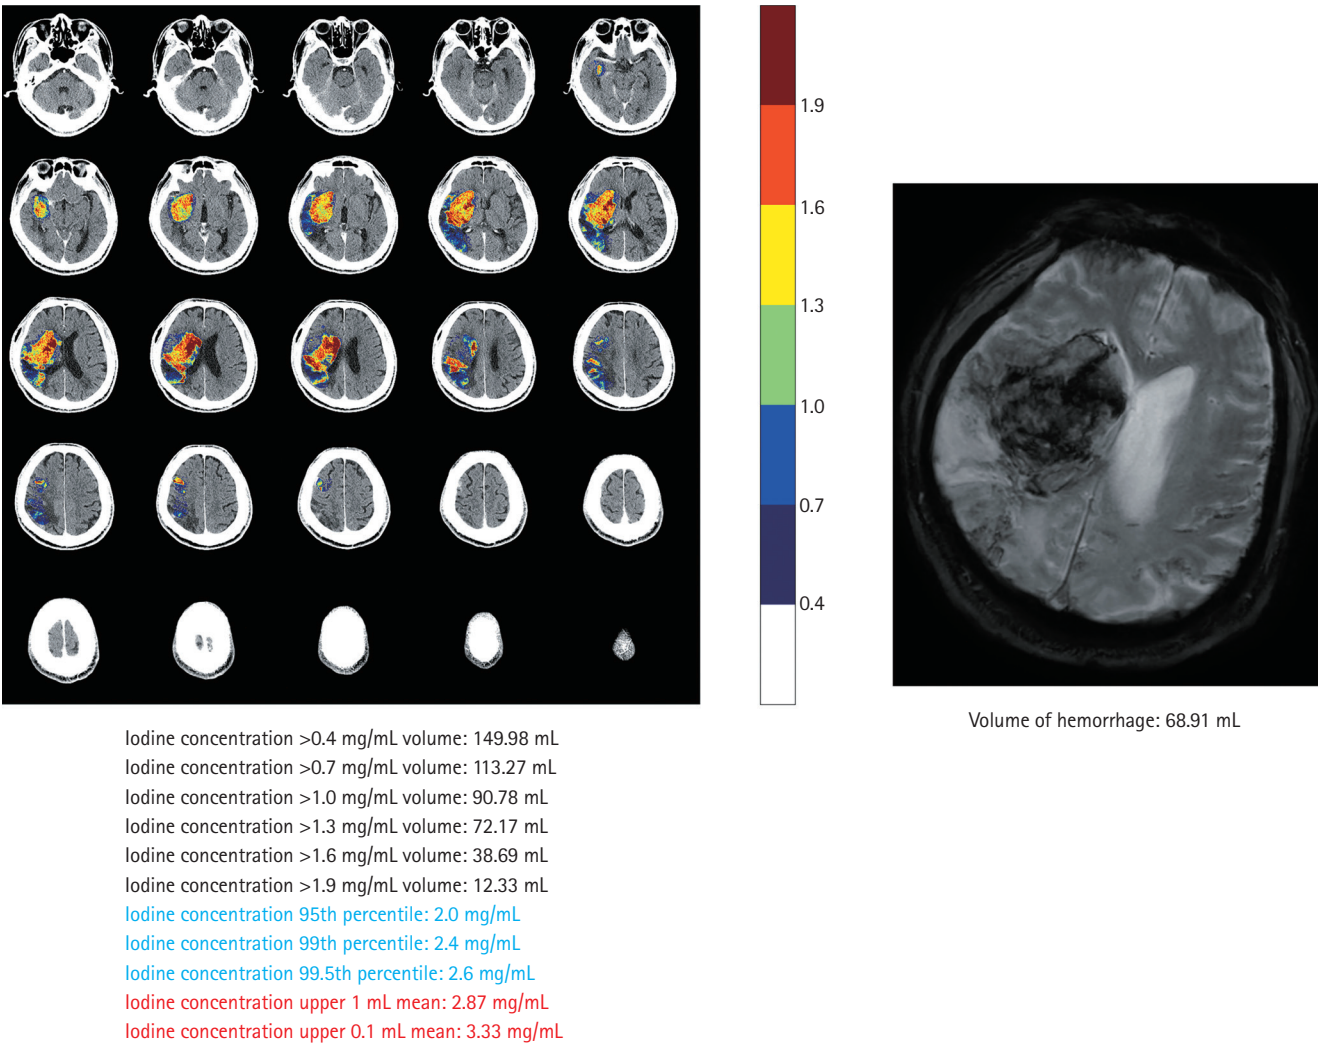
Iodine extravasation markers on dual-energy computed tomography and comparison with gradient echo imaging.
